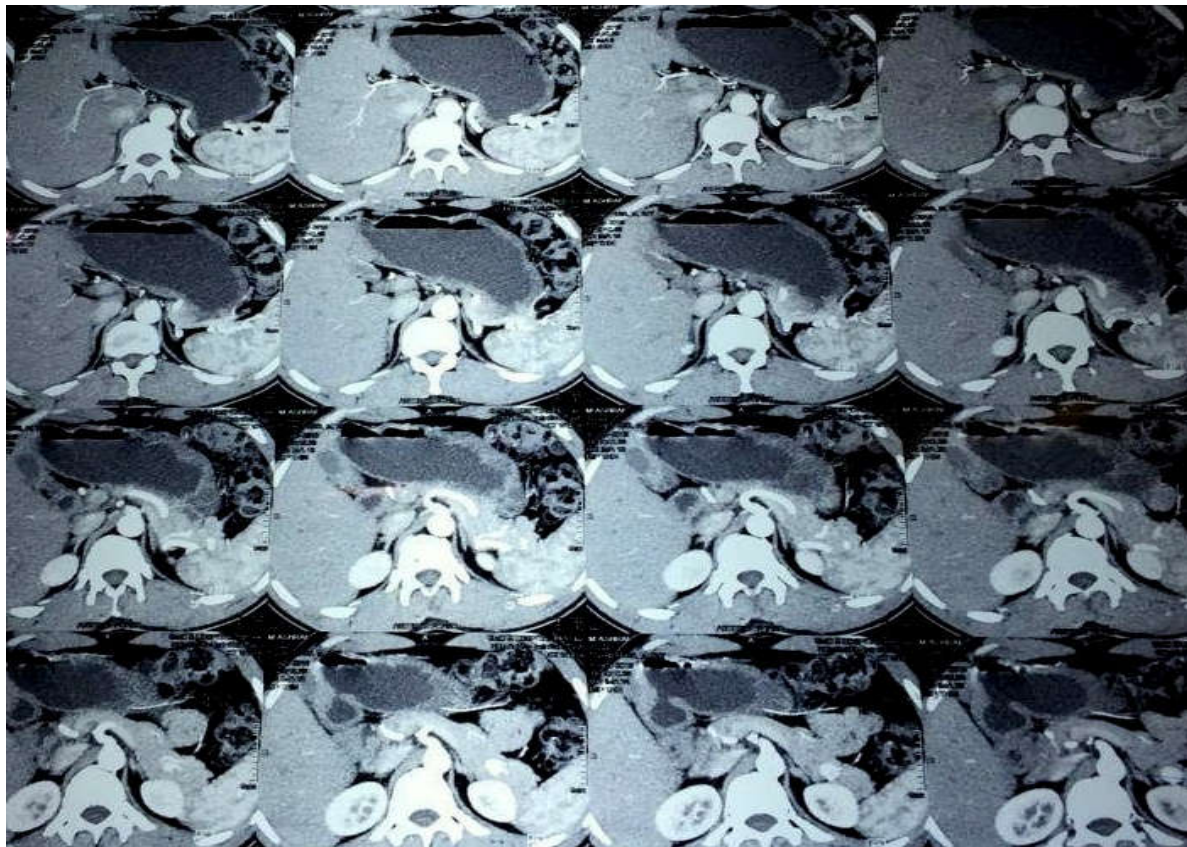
Contrast enhanced CT showing small enhancing mass in tail of pancreas
